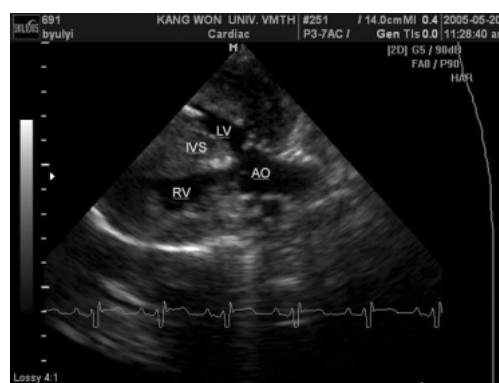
The 2 D echocardiography showing overriding aorta.
